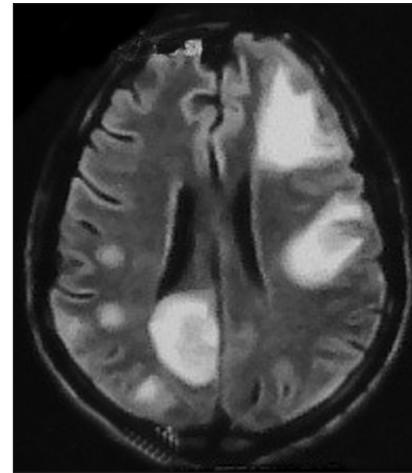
MRI brain of case 2 showing multiple, variable-sized, thin-walled enhancing lesions with peri-lesional edema
